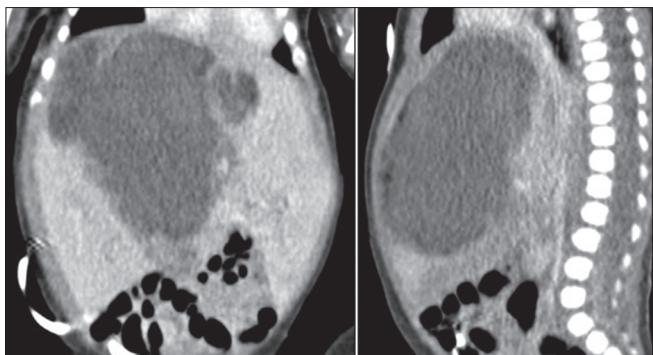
Abdominal CT scan of abdomen with intravenous contrast at 17 days of age revealing a large cystic liver lesion with irregular borders and small hypoechoic regions representing air. The lesion measures $72 \times 80 \times 38$ mm
